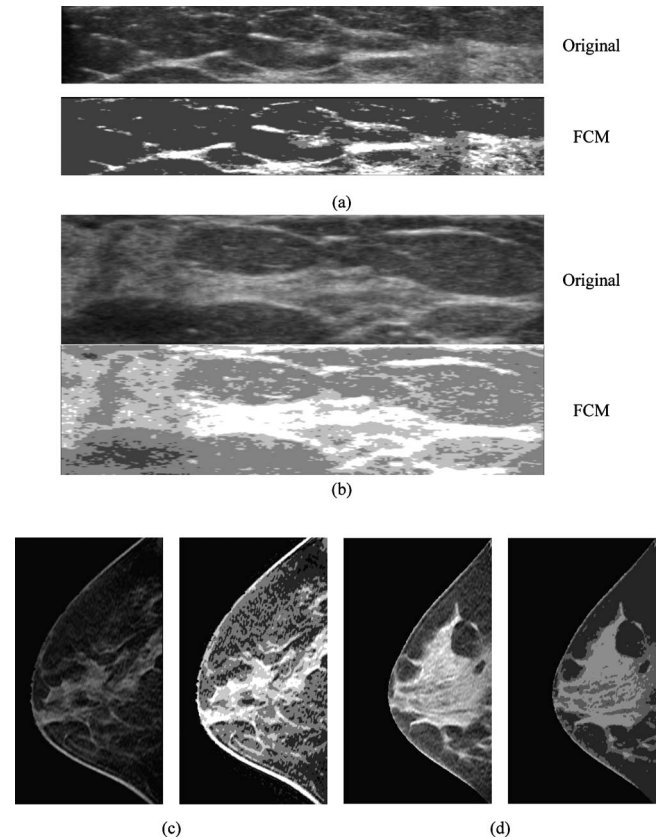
(a) The original image and the result of FCM classifier on ABUS for a BIRADS mammographic density grade 2 case. (b) The original image and the result of FCM classifier on ABUS for a BIRADS mammographic density grade 3 case. The breast density is 30.28%. (c) The original image and the result of FCM classifier on MRI for the case in (a). The breast density on MRI is 18.66%. (d) The result of FCM classifier in 3-D breast MRI image for the case in (b). The breast density of 3-D breast MRI image is 35.68%.
